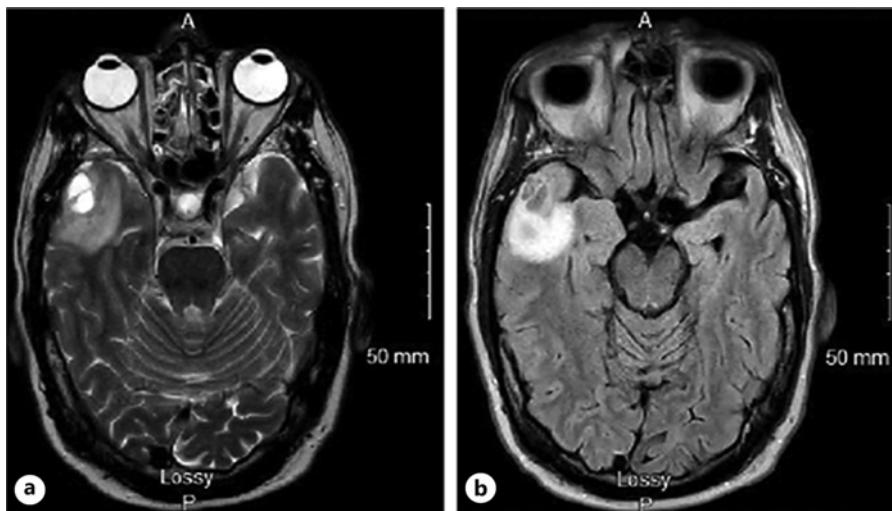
Axial magnetic resonance imaging (T1 with contrast (a), T2 FLAIR (b)) demonstrating the identified 2.3 cm cystic/solid lesion in the right anterior temporal lobe with moderate surrounding vasogenic edema appreciated. Findings were suggestive for metastatic disease originating from NSCLC primary diagnosis.
